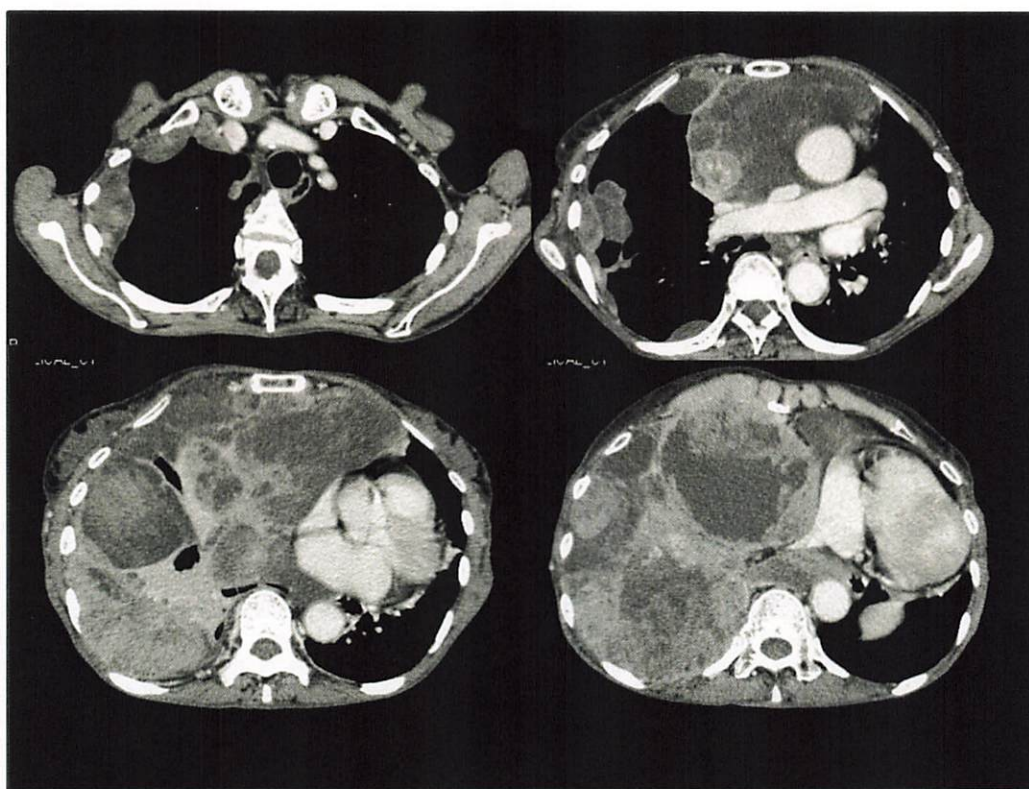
Contrast-enhanced CT scans of the chest (May 2010)
